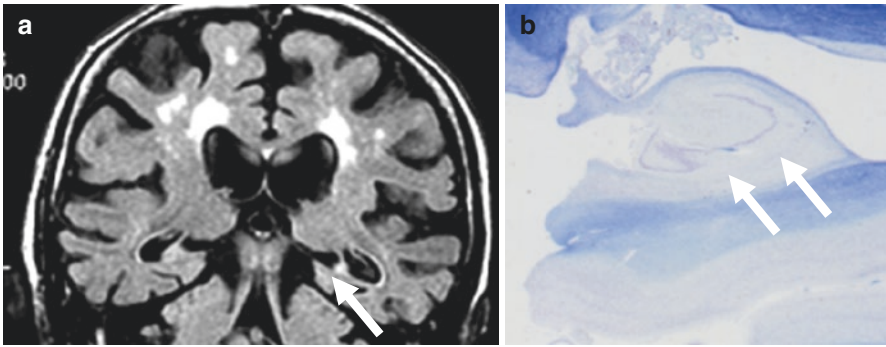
70s female, memory disturbance. On the coronal view of FLAIR, local atrophy and a high intensity of the right hippocampus were clear, suggesting hippocampal sclerosis
